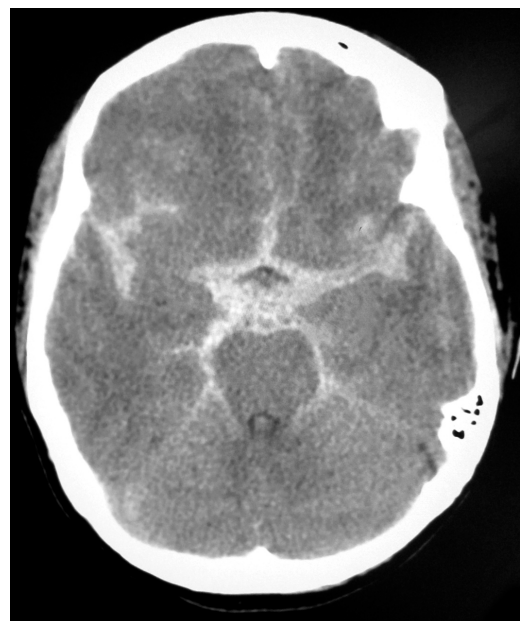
CT scan shows blood (white star-shape) in the subarachnoid space from a ruptured aneurysm.
